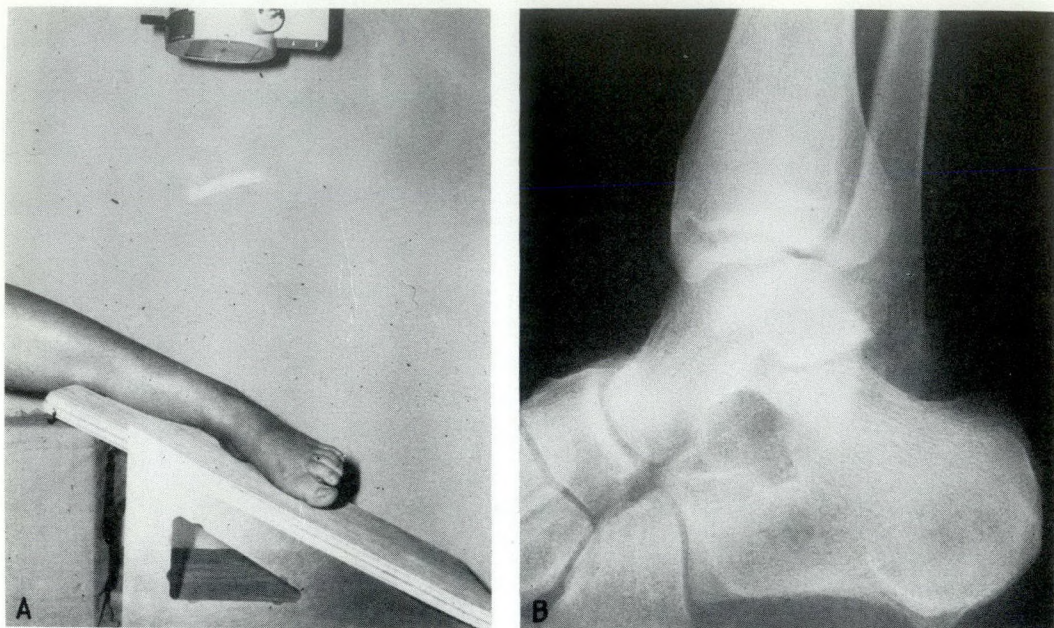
Special technique to visualize the subtalar joint without forced inversion—for use in patients with fractures of the os calcis. (A) Slanted plane to compensate for the absence of inversion and a lateral radiograph to visualize the posterior subtalar joint. (B) Radiographic visualization of the subtalar joint using the above technique (11A).
